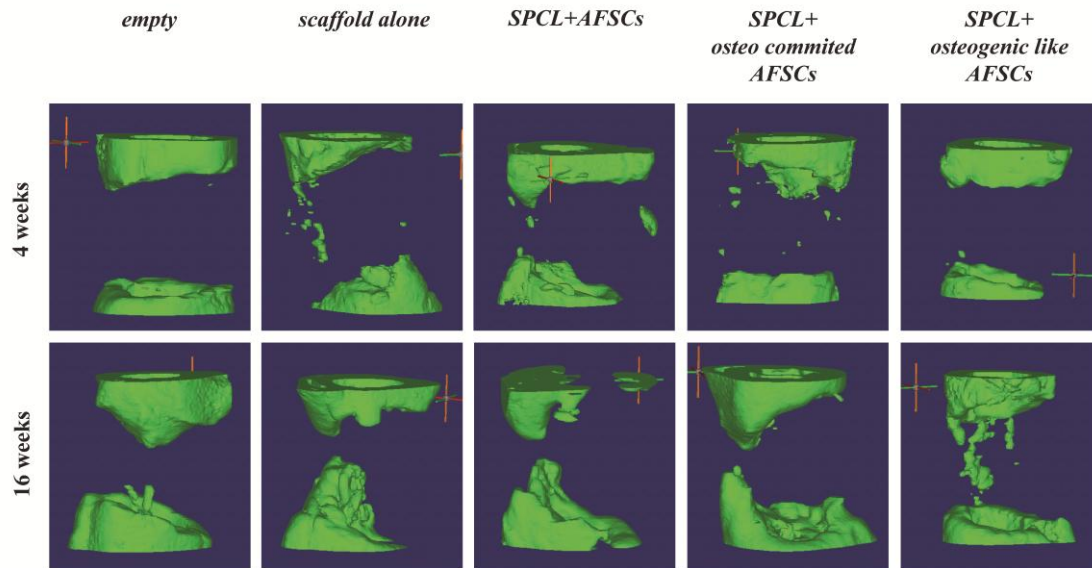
4.8 - m-CT images obtained from all defect conditions after 4 and 16 weeks of implantation.
